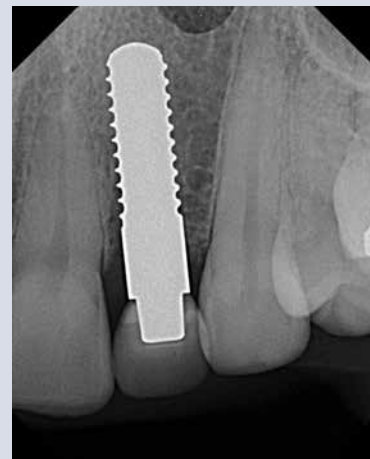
Three-month radiograph. Nearly no bone remodeling is seen.
